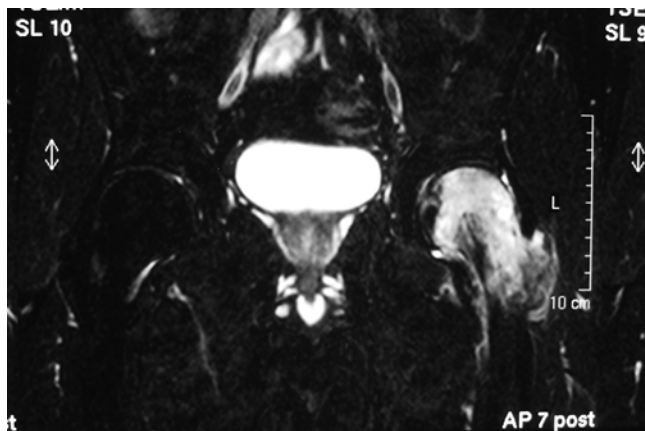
MRI findings (fat suppression, fluid sensitive sequence) of bone marrow edema syndrome showing marked, bright, hyperintense signal in left femoral head and neck
